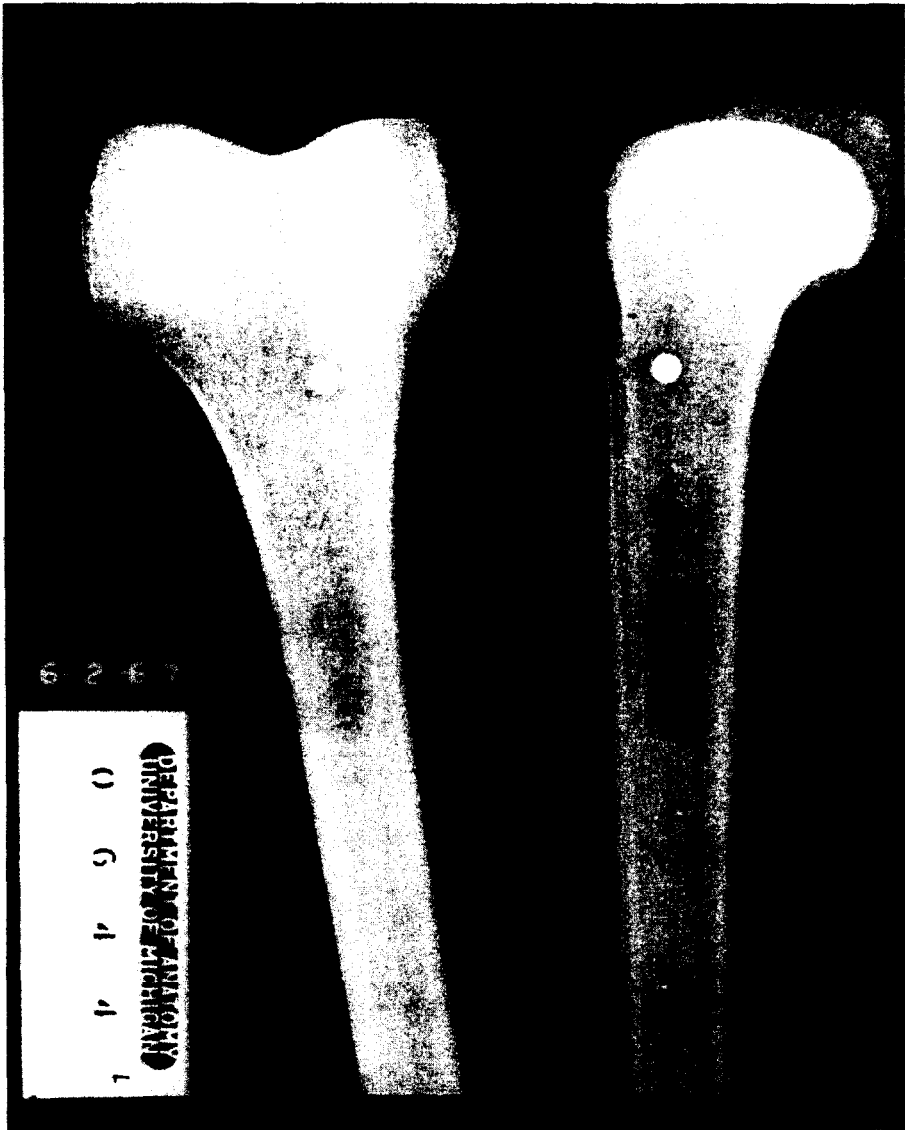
Radiograph of a mildly osteoporotic femur impacted at a velocity of 508 ft/sec by a 0.250 in. sphere. The left-hand image is a posteroanterior view. The right-hand image is a right lateral view, and in this view the projectile entered the bone from the right.
